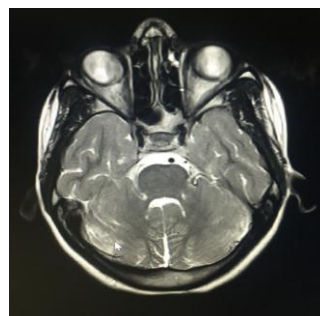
MRI brain showing Molar tooth sign, cerebellar vermis hypoplasia
